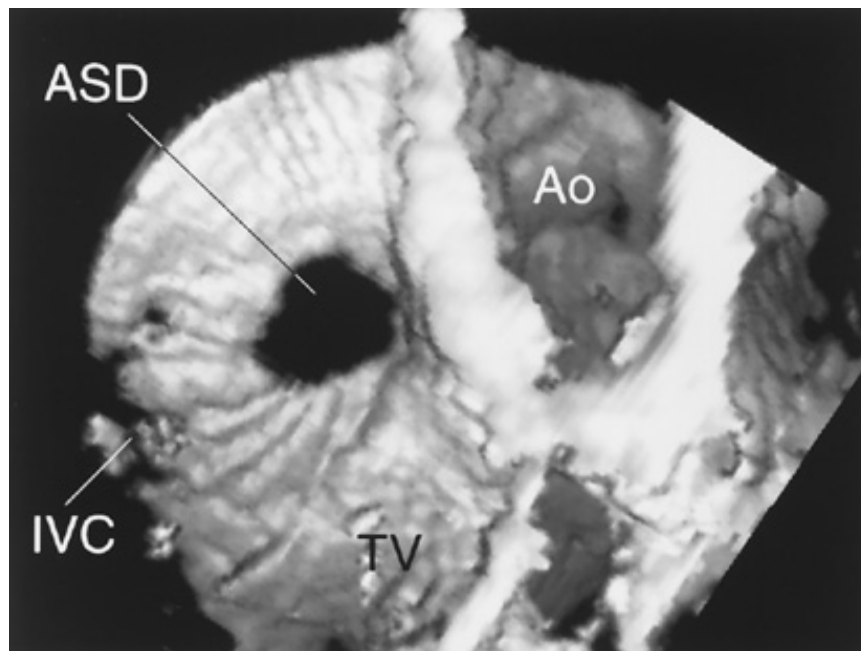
Three-dimensional echocardiogram of a secundum atrial septal defect (ASD). This is a right atrial en-face view that shows the size, shape, and position of the defect in relation to the right atrial septal surface. Ao = aortic valve; TV = tricuspid valve; IVC = inferior vena cava. Courtesy of Dr. Gerry Marx.
